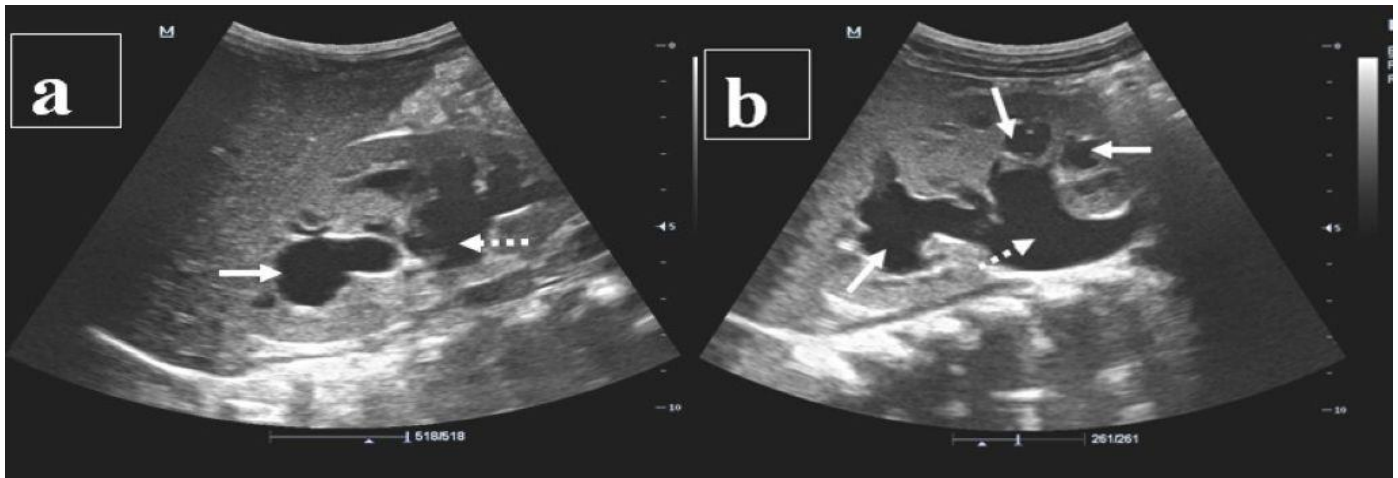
Longitudinal ultrasound of the right (a) and left (b) kidneys demonstrating marked dilatation of the calyces (solid arrows) and renal pelvis (dashed arrows)
